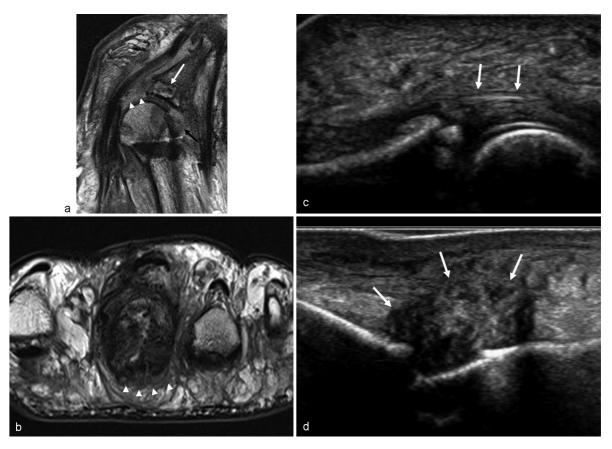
A 68-year-old woman presents with persistent pain and swelling 1 year post second MTP joint plantar plate repair. (a) Sagittal protondensity (PD) MR image demonstrates widening of the drill hole in the base of the proximal phalanx (arrow), an edematous plantar plate (arrowheads), and proximal capsulo-synovial thickening at the dorsal recess (black arrow). (b) Short-axis T2 MR image and (c) sagittal ultrasound images confirm there is no dehiscence of the plantar plate repair. (d) Sagittal ultrasound image confirms the prominent capsulo-synovial thickening in the dorsal recess of the second MTP joint.
